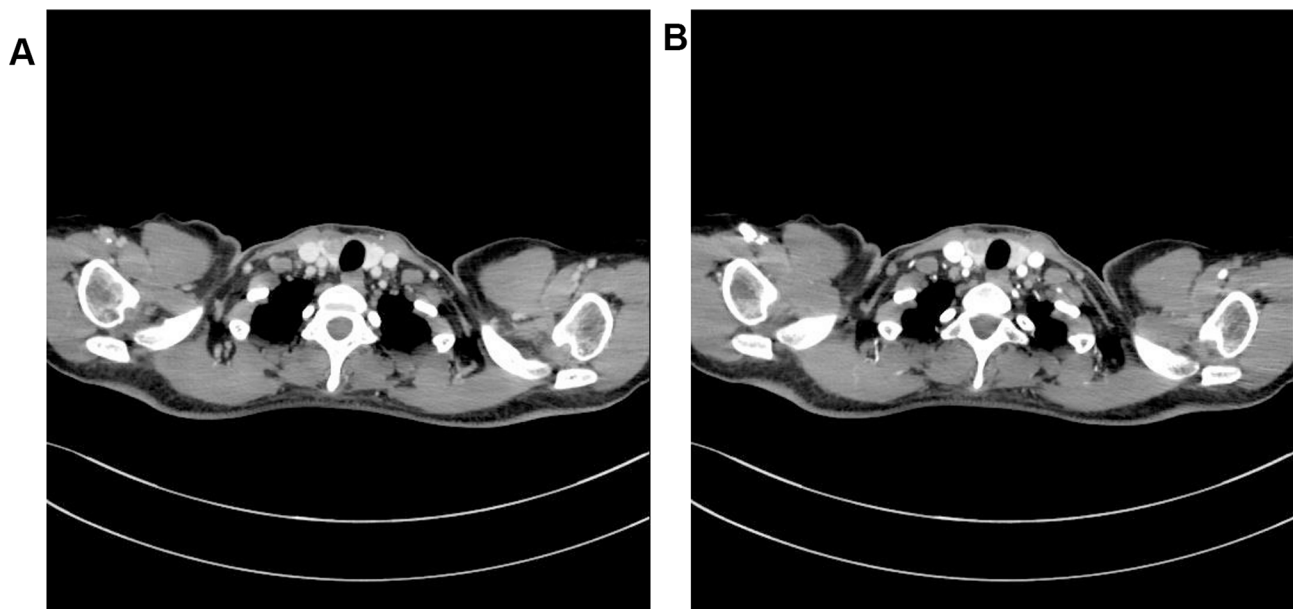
Computerized Tomography (CT) imaging showed hypoechoic lesions in the right lobe of the patient's thyroid gland
